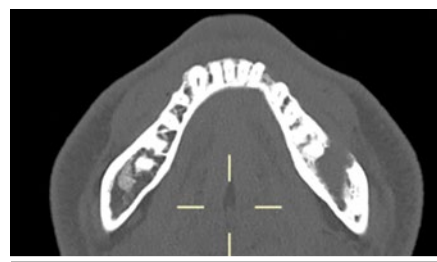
Dental cone beam computed tomography (CBCT). Axial view of mandible showing radiolucent lesion in the 37 region with erosion of the left buccal cortical plate. The lesion had an intimate association with the inferior dental canal with no intervening bone
